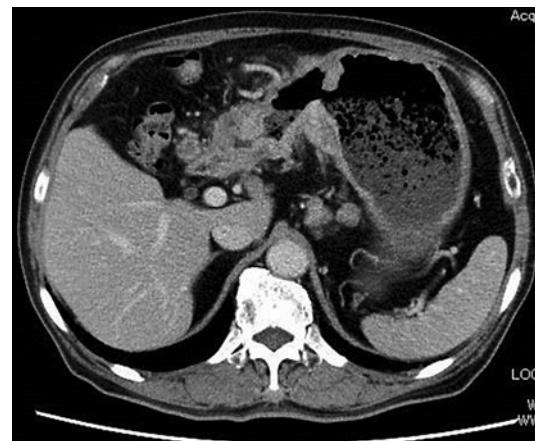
CT abdominoplasty. CT scan at the initial examination: wall thickening was observed in the gastric horn to pyloric anterior wall kyphosis. The pyloric region was narrowed by the tumor, and the stomach was dilated at the mouth. Multiple enlarged lymph nodes were observed around the greater and lesser curvatures of the stomach.
